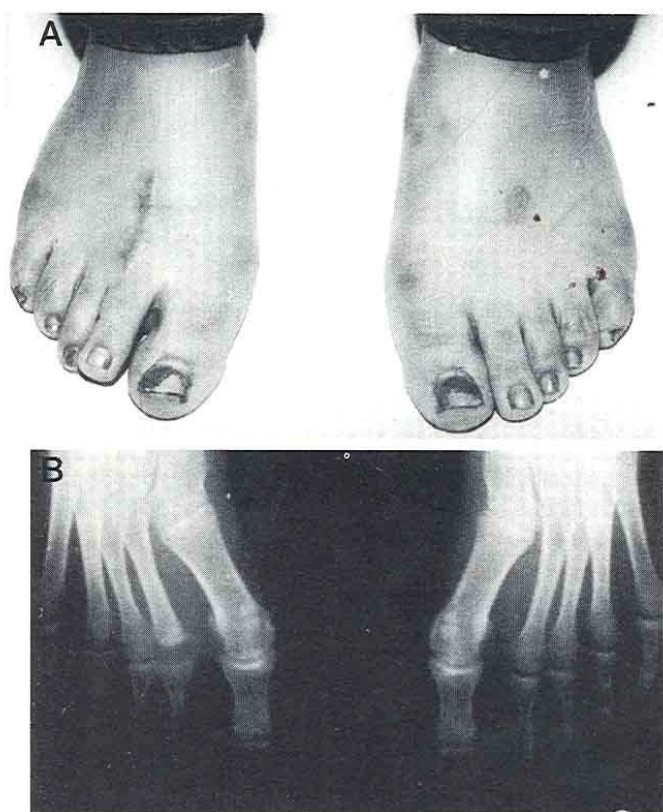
Late follow-up appearance and radiographic study of the right foot with second metatarsal head infraction, showing maintained length of the second toe.
